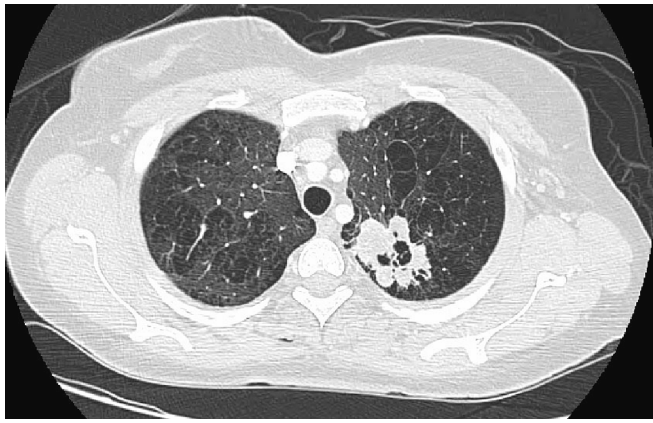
This staging chest computed tomography (CT) demonstrates pulmonary metastases in the left upper lobe measuring 4.3×3.8 cm. Additional metastases were noted in the right upper lobe (not pictured).
